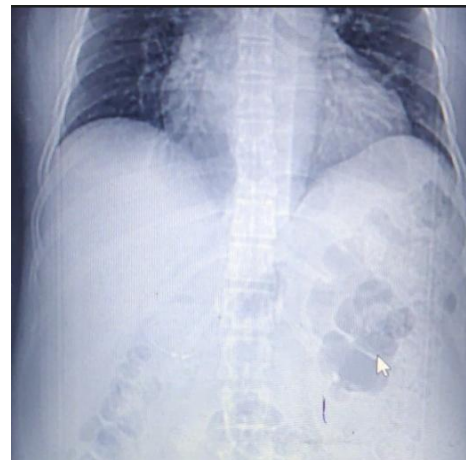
Chest X-ray showing the foreign body
